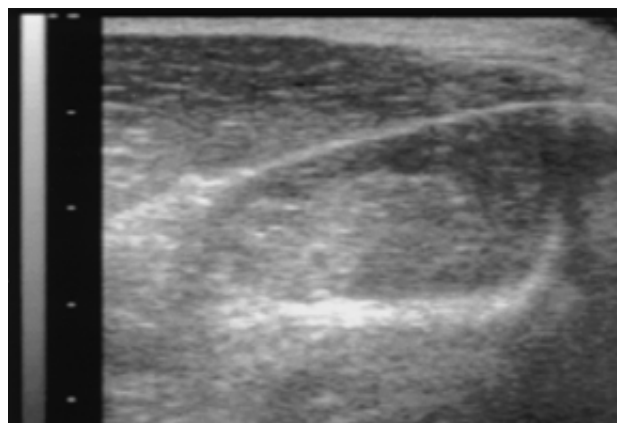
B-mode image of the supraspinatus in diagnostic ultrasound
